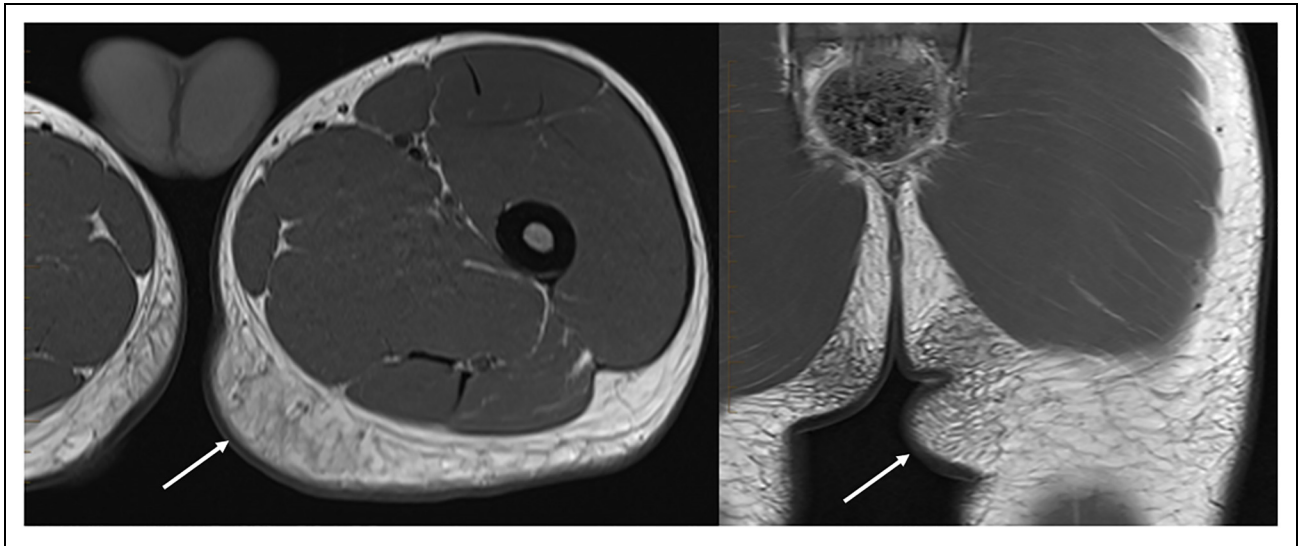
(Patient #2): MRI lower extremity showing axial and coronal T1 images. Axial and coronal T1 images of the left upper thigh/buttock region demonstrates asymmetric prominence of the superficial fatty tissues with reticulation in the posteromedial left buttock region (long arrows). No well-defined mass or lipoma.
